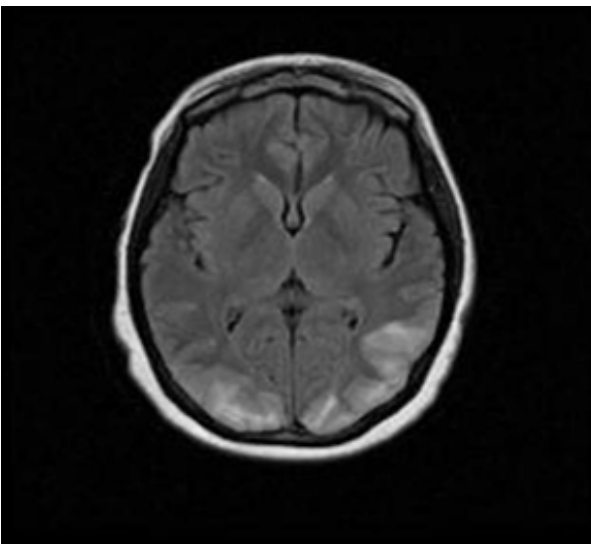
Hyperintense lesion on T2 weighted MRI over parietal and occipital area
